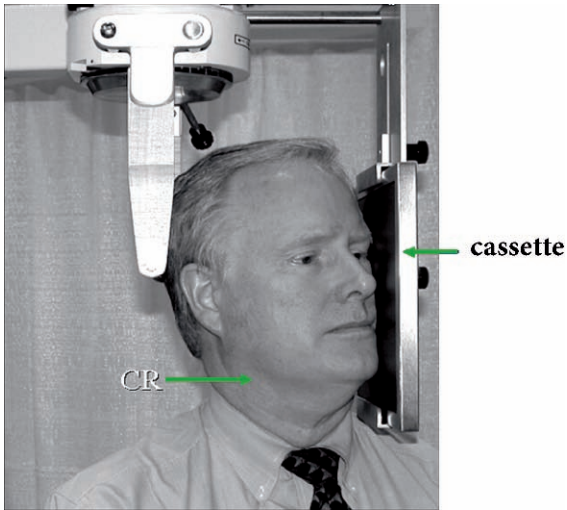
Lateral-oblique projection of the jaw. The lateral-oblique projection often necessitates the cassette being held by the patient to achieve the desired X-ray beam angulation. CR Central ray
